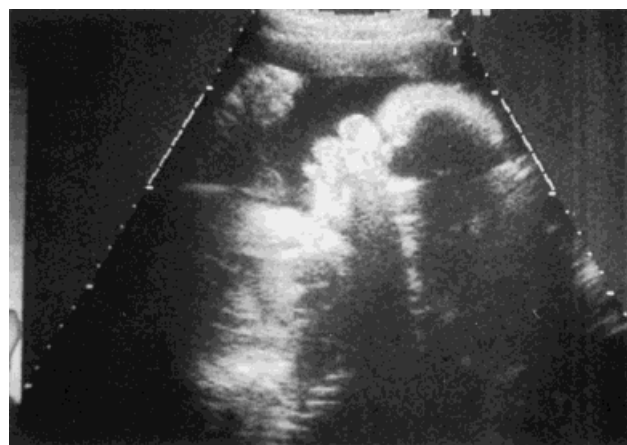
Ultrasound examination of a 20-week fetus showing bulging nose, long philtrum, and micrognathia.
